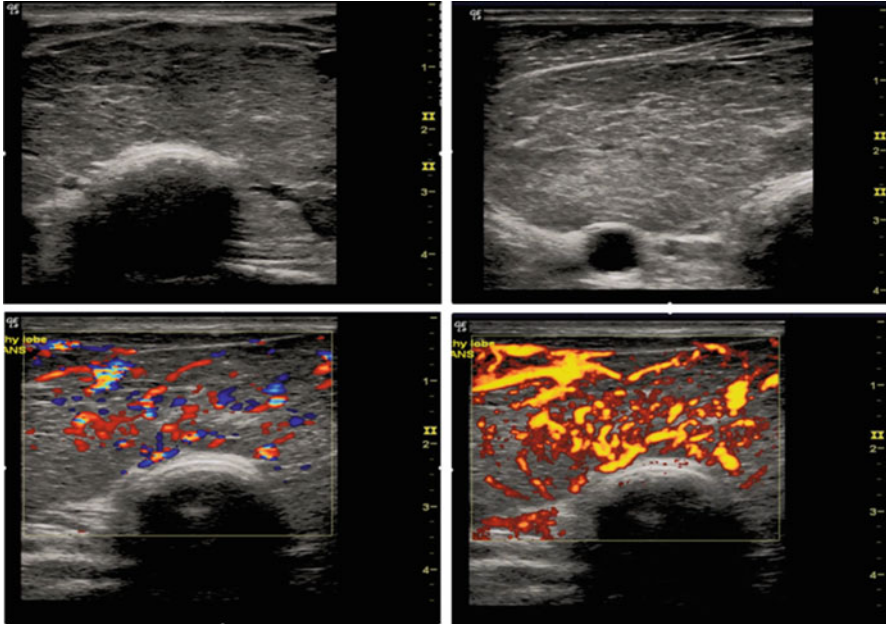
Thyroid gland of a patient with Grave's disease. Top: B-mode midline-transverse (left) view and right lobe (right). Bottom left: color flow Doppler, right: power Doppler. Color flow Doppler imaging shows marked hyper vascularity
